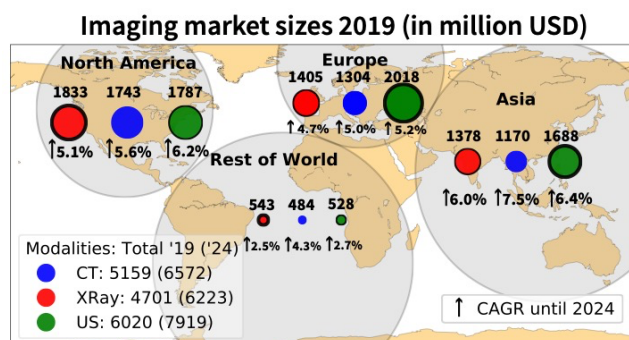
Regional sizes of medical imaging markets. Overall, US has the largest market across all modalities and is especially dominant in Europe. CT instead is dominant in North America, but CAGR for US are higher and a turn-around is predicted until 2024. The circle radius is proportional to the market size, but for visual clarity, thickness of black borders resembles the regional rank per modality. Figure was created with data from: <https://www.marketsandmarkets.com/>, Diagnostic Imaging Market - Forecast To 2024.
